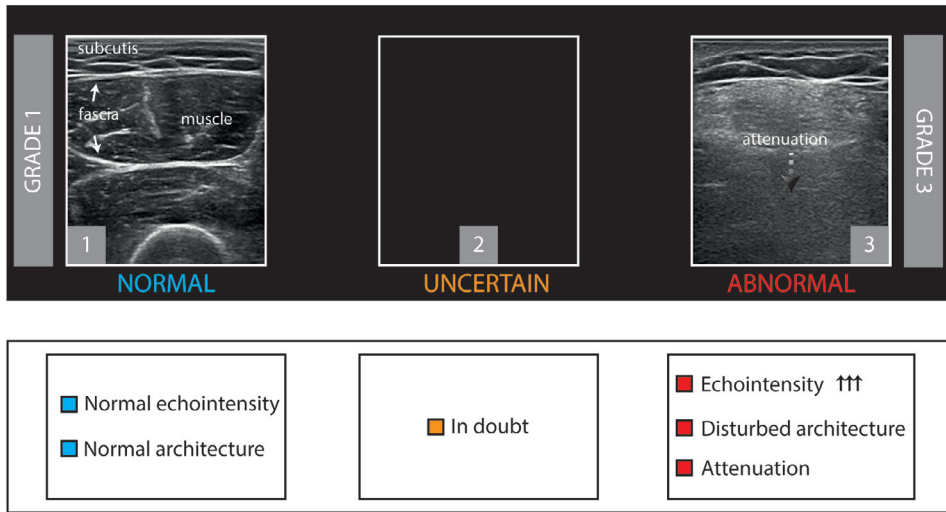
3-point muscle ultrasound grading scale. If echo intensity and architecture are found to be normal, the muscle is graded normal (grade 1). If there is pronounced increase in echo intensity, loss of normal muscle architecture and occurrence of attenuation, the muscle is graded abnormal (grade 3). When in doubt, the muscle can be graded as uncertain (grade 2).
